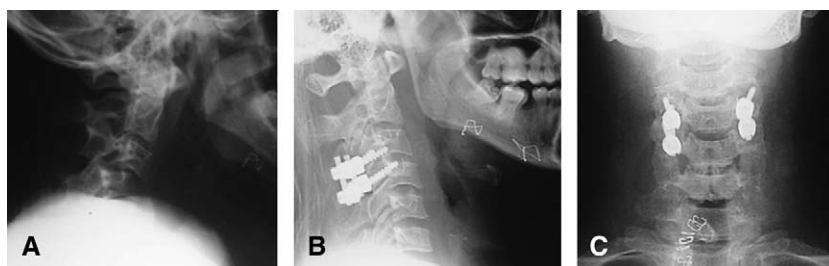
(*A*) Preoperative lateral radiograph demonstrates C3-to-C4 subluxation. The patient was taken to the operating room after partial reduction in traction, where drilling of the C4 superior facets allowed intraoperative reduction with placement of C3-to-C4 lateral mass screws. Postoperative lateral (*B*) and anteroposterior (*C*) radiographic views confirm proper cervical realignment and screw placement.
